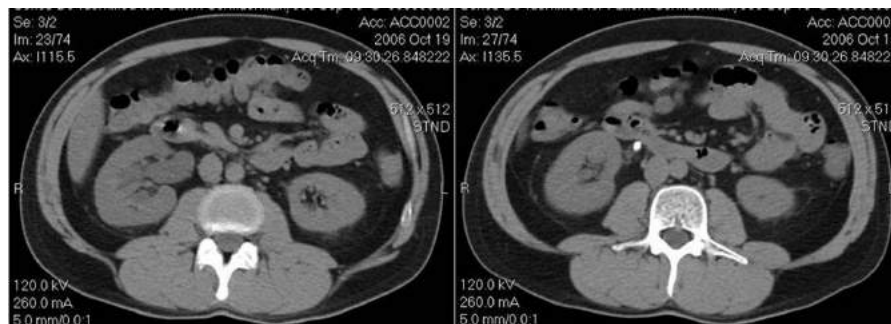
Two images from CT-KUB series showing calculus in the PUJ/upper ureter producing obstruction and hydronephrosis.
